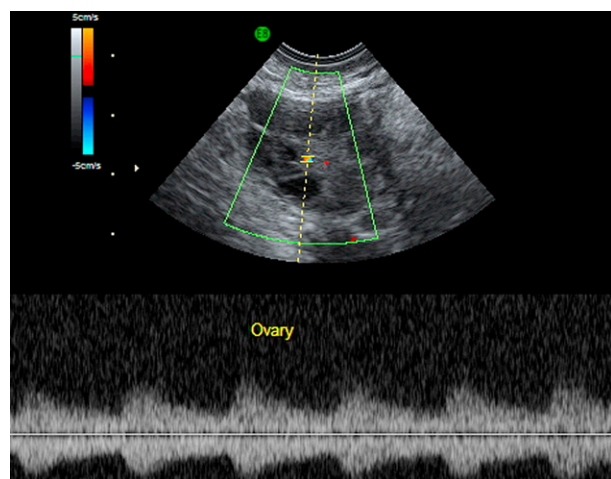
Doppler blood flow velocimetry of the ovary - central area.
